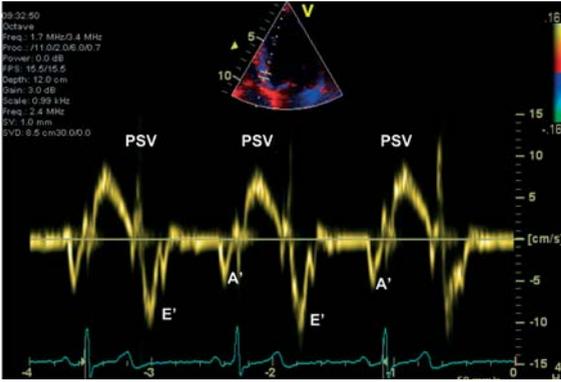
Pulsed-wave tissue Doppler imaging of a normal individual
